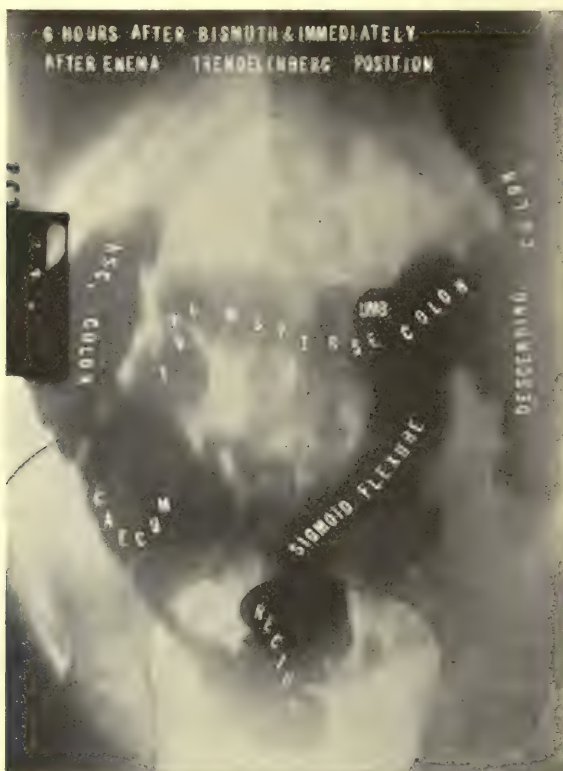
Same patient after 5 minutes in *Knee-chest position*—then turned over and radiographed in Trendelenburg position—this combined method known as Wm. P. Healy's. Note the umbilicus has dropped toward the patient's thorax and to the left. Taking the constant line between the iliac crests (superior) as the level of normal umbilicus. We find in Fig. 88 the transverse colon lay  $1\frac{1}{2}$  inches below the line while in Fig. 89 it lies 3 inches above this line, or  $4\frac{1}{2}$  inches change in posture. This demonstrates no adhesions bending the gut in the pelvis, but the same narrowing due to probable adhesion is shown at + in Fig. 89. Mrs. X.
